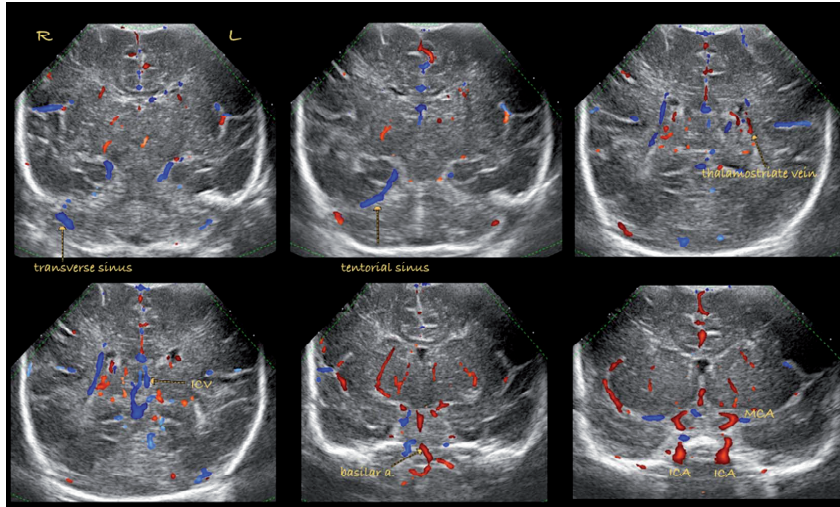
Coronal Doppler
